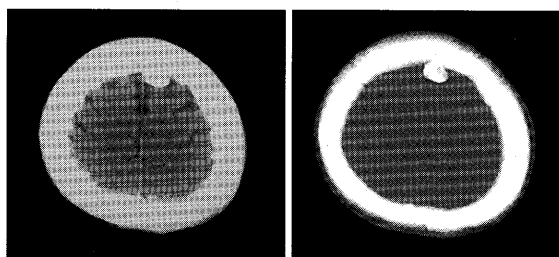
Axial computed tomography scans (*left*: planar, *right*: bone window) showing a well-circumscribed high density extra axial mass at left parasagittal aspect of the dura mater mimicking osteoma and/or calcified meningioma
